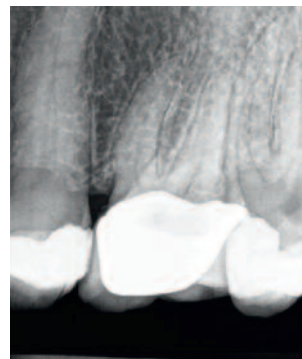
Radiographic examination 1 year post-treatment. The tooth remained free from any periapical pathology (the third molar # 28 was removed in the meantime due to recurrent caries)
